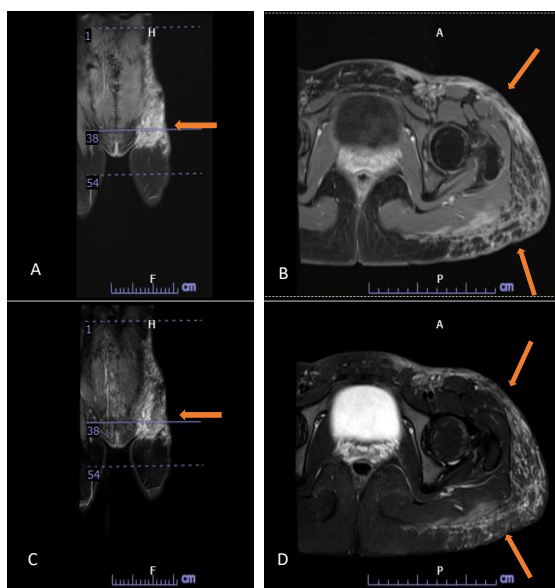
The MRI revealed high signal intensity enhancement and diffusion restriction along the fascia of the subcutaneous tissue around the left hip, lower back, and left buttock, involving the posterior aspect of the left gluteus maximus and the left lateral tensor fascia latae muscle.
